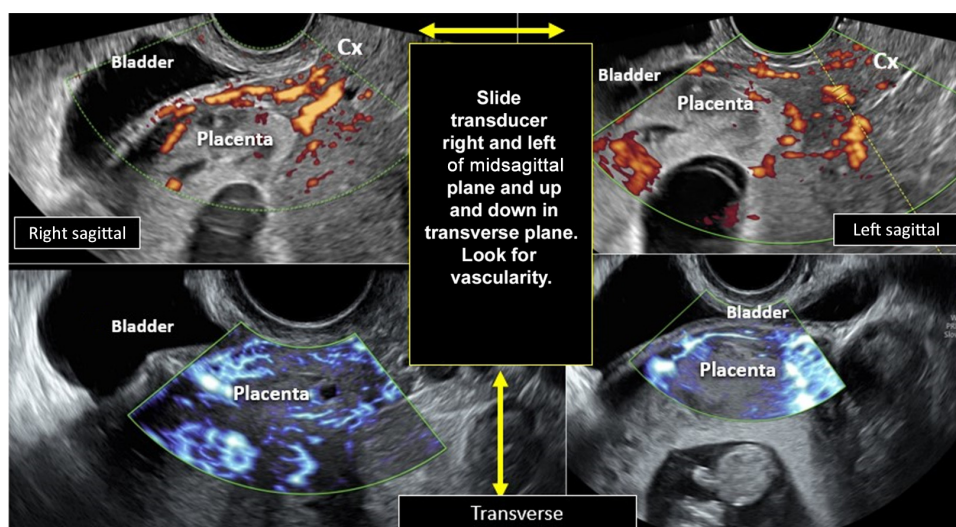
Transvaginal ultrasound images very similar to those in Figure 4, but with color Doppler mode turned on to evaluate quality and density of placental blood vessels in area between bladder and gestational sac. Cx, cervix.
